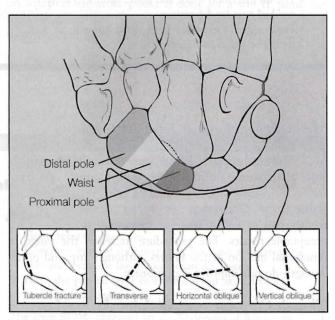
A dorsal view of the scaphoid bone demonstrates various fracture orientations. Determining the orientation on radiographs is important because the orientation helps guide treatment decisions. (From Gutierrez G: Office management of scaphoid fractures. Physician Sports Med 24[8]:60, 1996).
